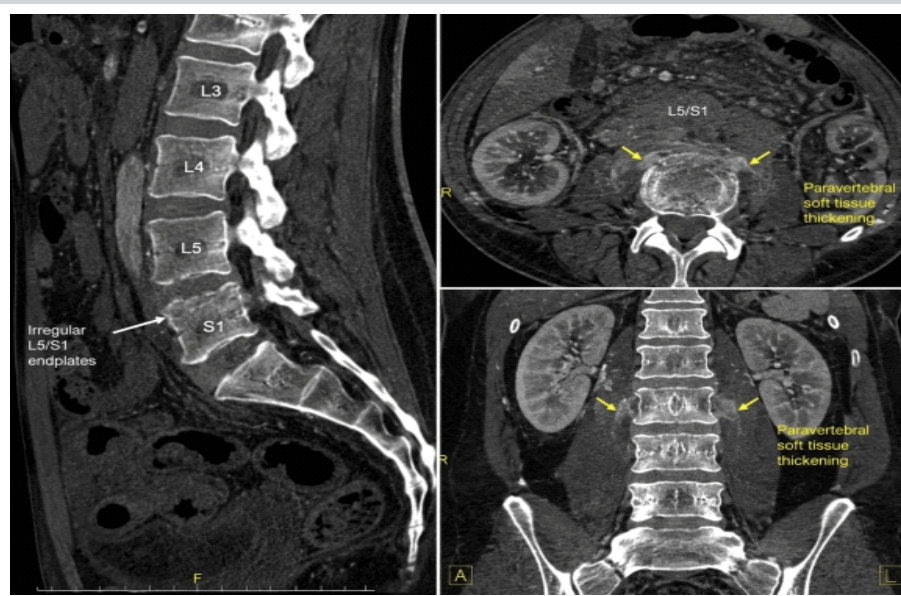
Contrast-enhanced computed tomography of the lumbosacral spine demonstrating irregularity and erosive changes of the L5/S1 vertebral endplates with adjacent paravertebral soft-tissue thickening, consistent with early spondylodiscitis. No definite drainable epidural or paravertebral abscess is identified on computed tomography.
